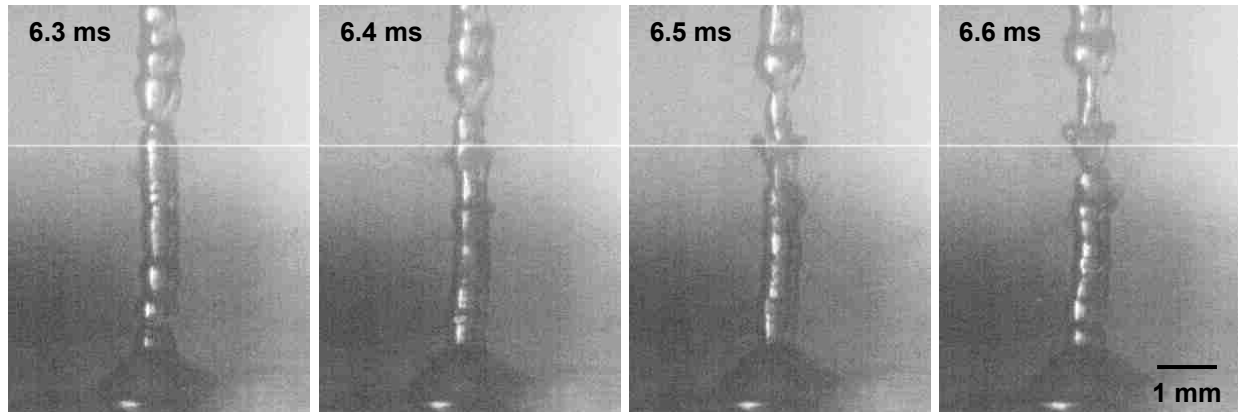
Selected frames from a high speed video of water atomization when the static pressure was reduced to atmospheric after being exposed to 2000 psi of overpressure. In this case, one of the middle droplets explodes and releases jets out to either side of the drop chain. The droplets that are emitted are less than one pixel in size ($20\ \mu\text{m}$), and are emitted with a velocity of 6 m/s. The drop chain is approximately 0.75 mm in diameter and propagates vertically at 1.75 m/s. The ultrasound exposure was 10-ms in duration with an intensity of $350\ \text{W}/\text{cm}^2$ ($p_+ = 3.5\ \text{MPa}$, $p_- = 3\ \text{MPa}$).
